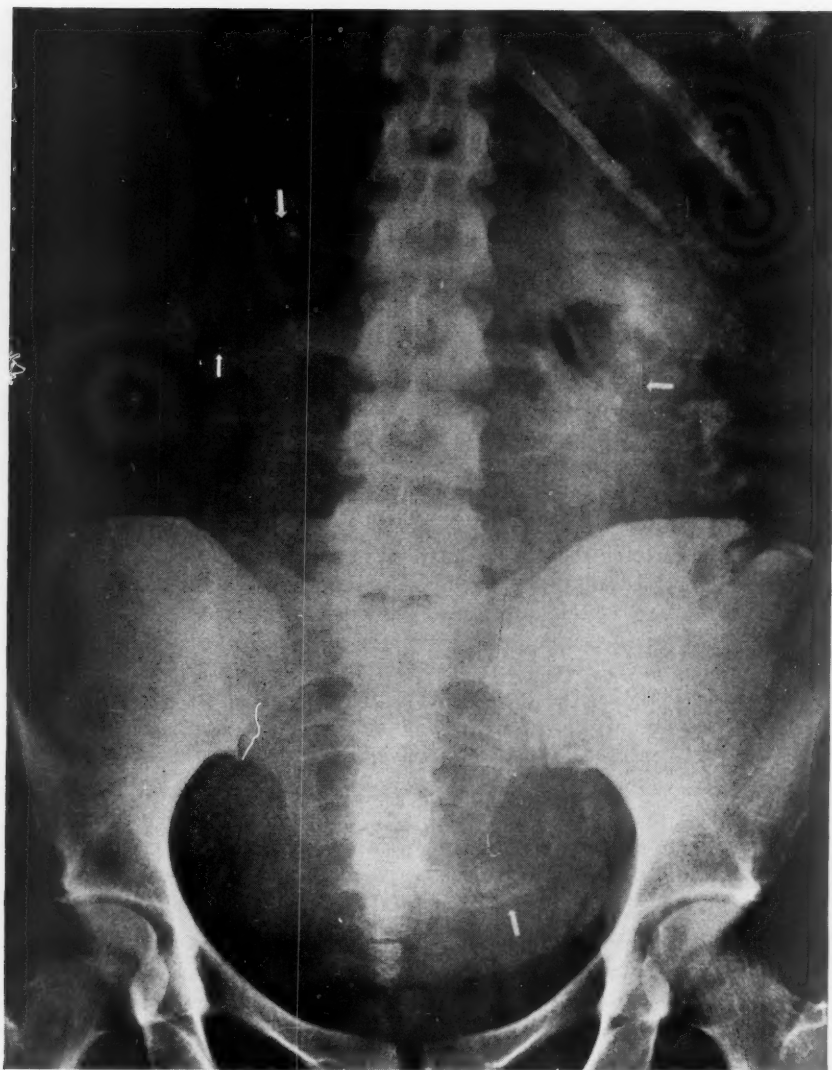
X-ray at 17 weeks' establishing early diagnosis of quadruplets. The long bones and spines are more visible than the skulls.
